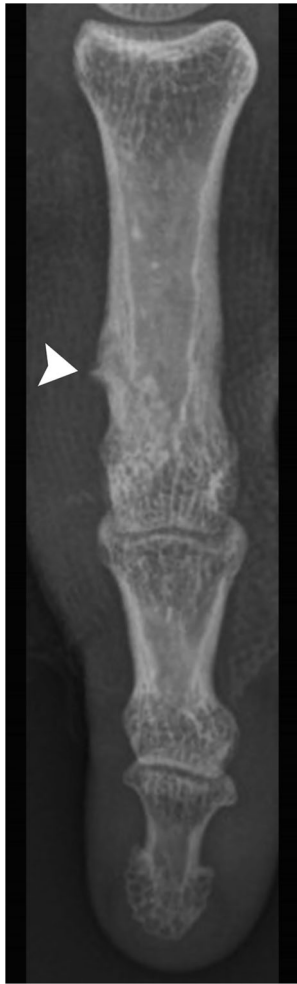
Frontal radiographic view of the third digit showing a focal soft tissue fullness medial to the proximal phalanx head with saucerization of the underlying cortex and subtle cortical buttressing at the proximal aspect of the lesion (arrowhead)
